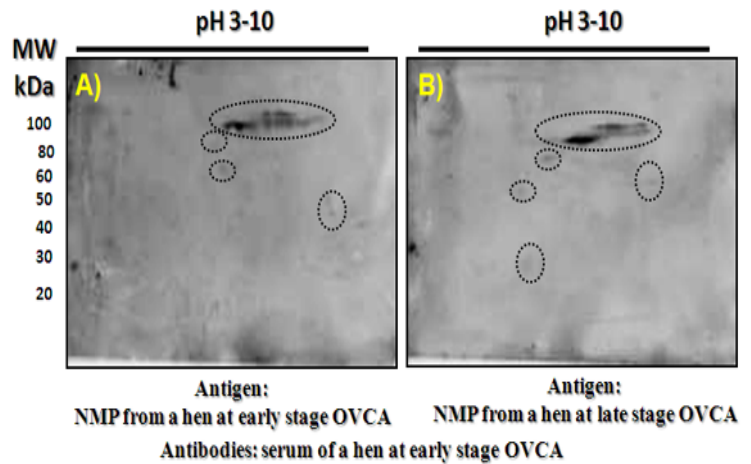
Detection of serum prevalence of anti-NMP antibodies in hens. Serum from a hen at early stage OVCA detected by IL-16-targeted molecular ultrasound imaging were examined against NMPs from heterogenous ovarian tumors A) at early stage and B) at late stage. Nuclear matrix proteins (NMPs) were resolved and separated according to their molecular weight (MW) and pH and immunoblotted by 2dimensional Western blotting, 2D-WB. The same OVCA serum reacted in similar patterns against the NMPs from early and late stage OVCA. Serum from OVCA hens specifically detected ovarian NMPs of 30-100kDa. These results suggest that malignant nuclear transformation is associated with the prevalence of anti-NMP antibodies in serum.
